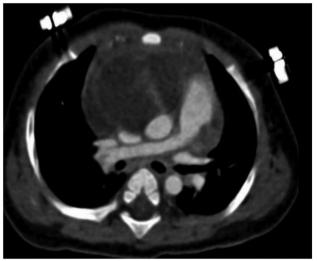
Thoracic computed tomography angiography image showing the tumor that displaces the superior vena cava, ascending aorta, and pulmonary trunk
